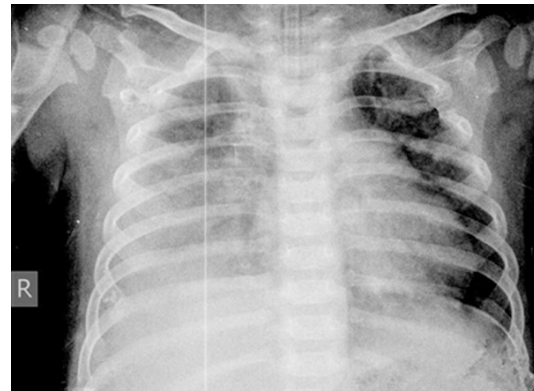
Several hours after admission, areas of parenchymal infiltrates were seen in both lungs in the infant's chest X-ray film.
